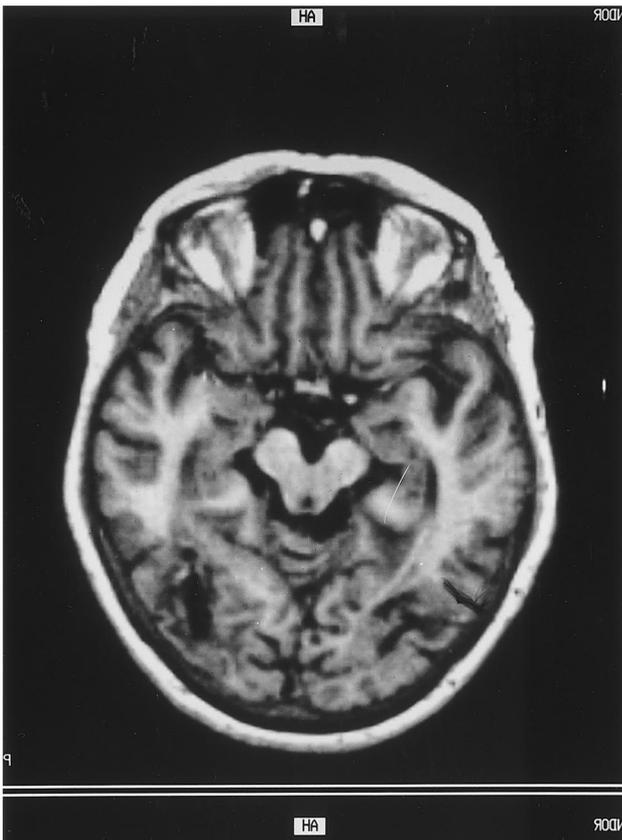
T1 weighted MRI scan showing symmetrical lesions in Brodman areas 11, 18 and 19 and in the underlying white matter. On the left side the lesion extends anteriorly to the inferior temporal gyrus (BA 37).
